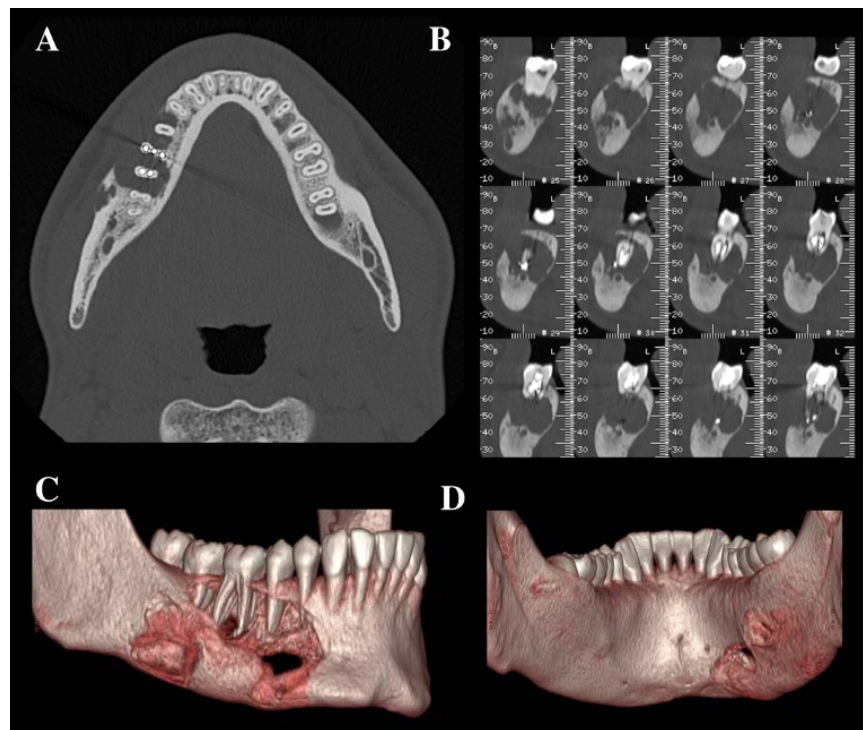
Multifocal osteolytic lesion of the jaw as it appeared at the time of the CBCT assessment
